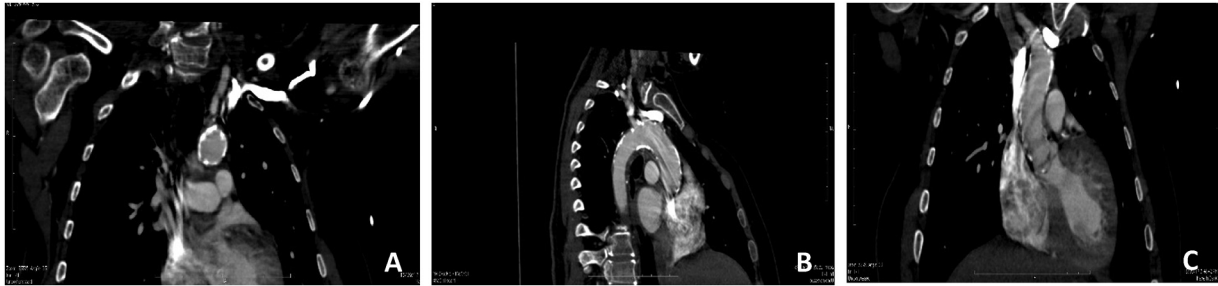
(A,B,C): CT scan images of Porcelain Aorta showing partial and circumferential calcification of ascending aorta and the arch in a patient of severe aortic stenosis.
